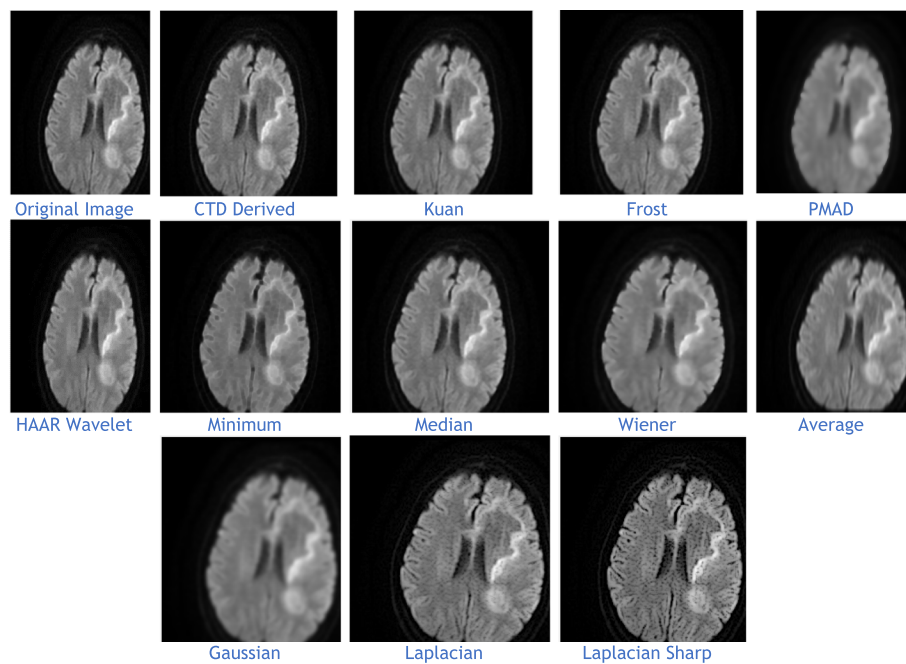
Denoised images of the brain MRI of Ischemic Demyelination disease for various filters and the proposed CTD filter
